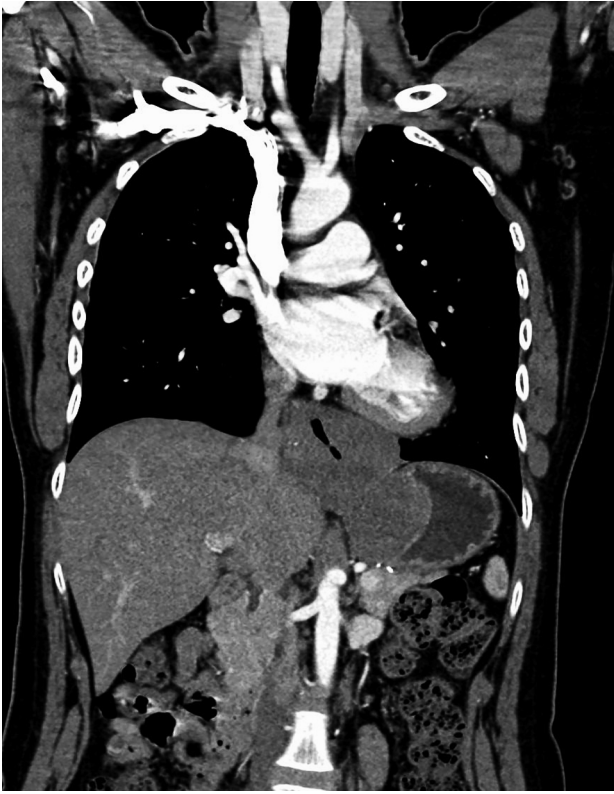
Contrast-enhanced computed tomography findings. Relatively homogeneously enhanced, giant tumours lie across the oesophagogastric junction between the lower thoracic oesophagus and the gastric cardia. Greatest tumour diameter is > 10 cm.
